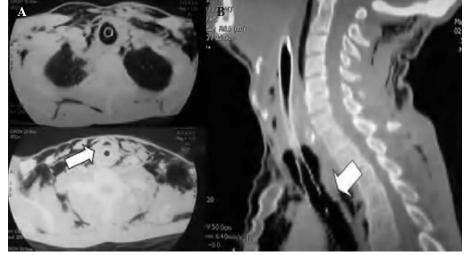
Computed tomography (CT) of the chest and cervical trachea of case 1. The patient's tracheal injury was caused by a knife. A: CT slice, where the arrow indicates the intratracheal air-fluid level. Significant mediastinal and subcutaneous emphysema. Chest tube inserted due to pneumothorax. B: Reconstruction of cervical CT, with an arrow indicating the injury to the cervical trachea.
